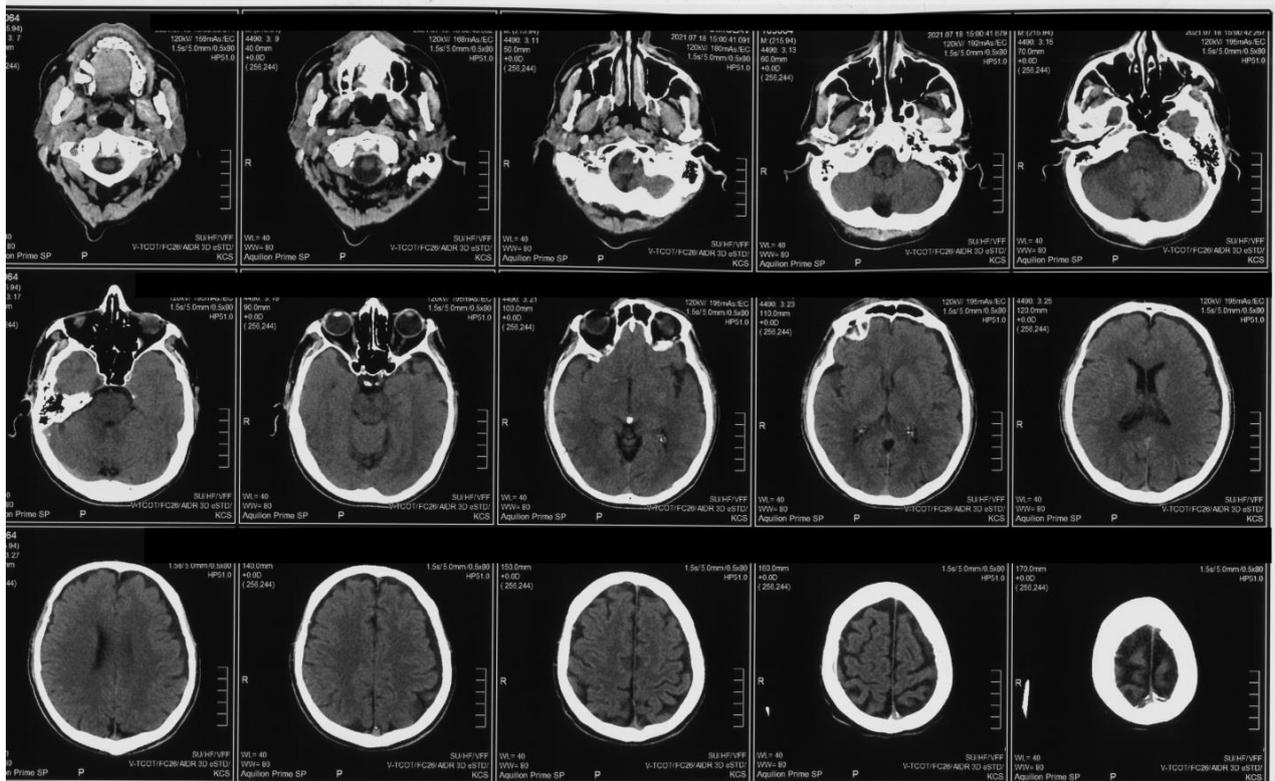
CT scan showed subarachnoid hemorrhage
